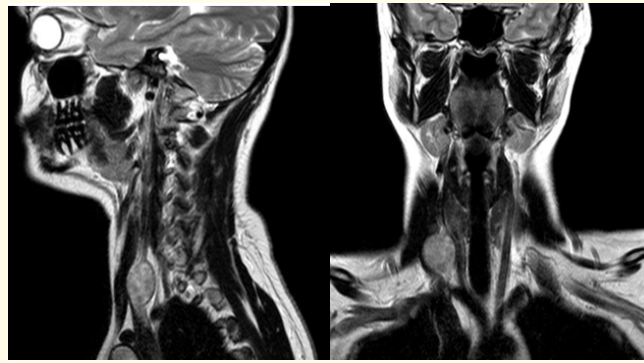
MRI of the neck with contrast in T2 slices 1. Sagittal and 2. Coronal.
